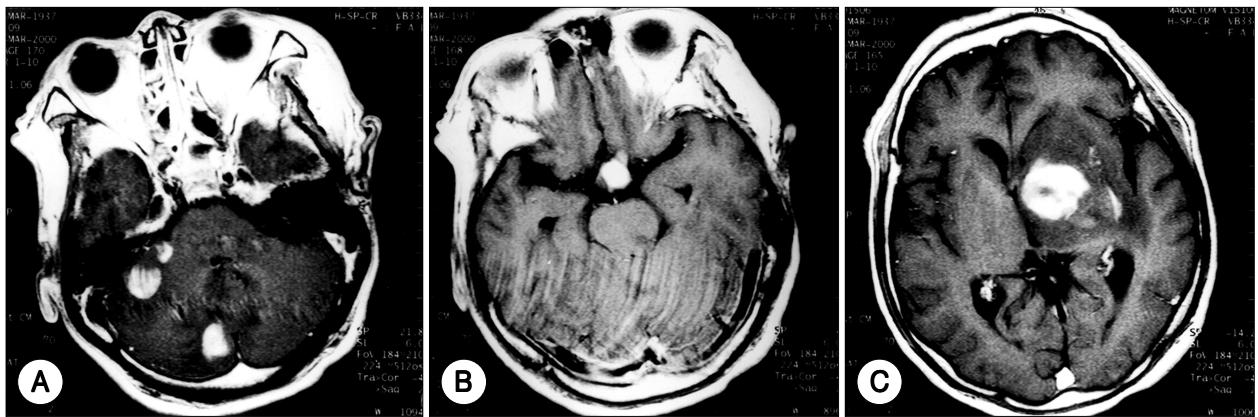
A 62-year-old immunocompetent man with primary central nervous system lymphoma in the basal ganglia, suprasellar, and cerebellum. Gadolinium-enhanced transaxial T1-weighted images obtained before stereotactic biopsy showing homogenous strong enhancing multiple lesions with minimal mass effect.
